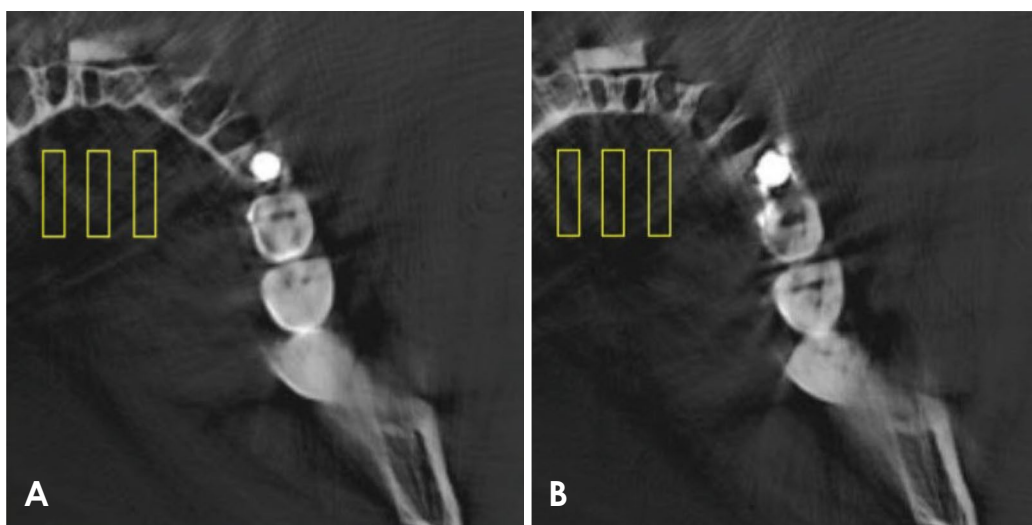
Selected regions of interest in ImageJ software with titanium (A) and zirconia (B) implants, positioned within the field of view on axial cone-beam computed tomography images.
